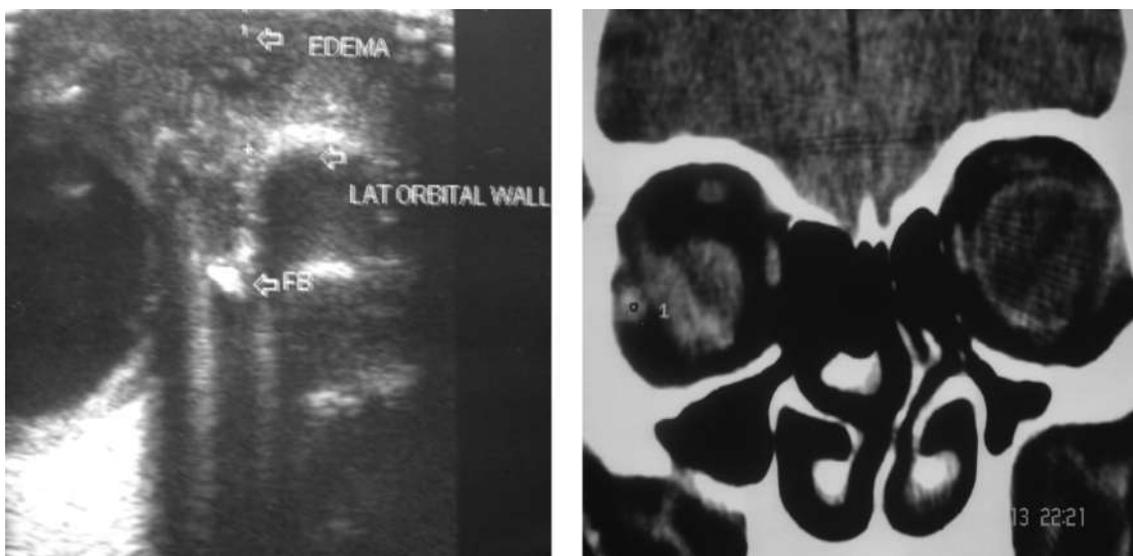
Intraorbital non radio-opaque foreign body with overlying soft tissue edema on USG (left) and CT (right)
